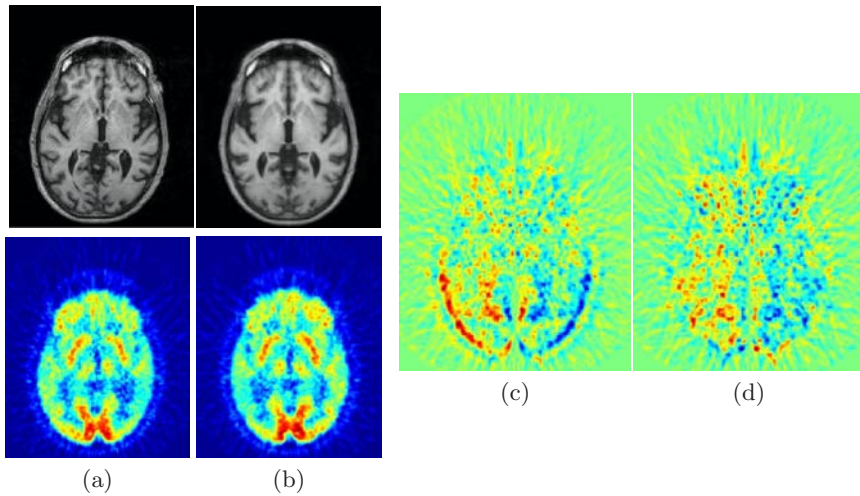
a) Axial slice of original MR image and the associated PET image. b) The symmetric structural image constructed using unbiased diffeomorphic averaging and the associated PET image transformed. c) Difference in the PET image and its reflection about the structural plane of symmetry. d) Metabolic asymmetry image modulo structural asymmetry, i.e., difference in the PET image and its reflection after mapping to the symmetric structural image space. Notice the reduction in the asymmetry signal due to removal of the structural asymmetry from the PET image. (See electronic version for color images.)
